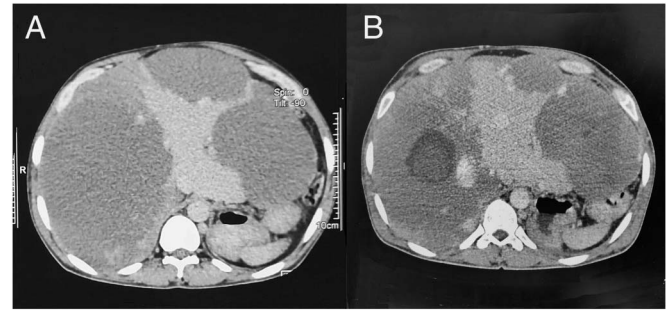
Multidetector computed tomography axial image of the patient's brother showing (A) multiple giant hemangiomas occupying the right and left liver and (B) after 1 session of radiofrequency ablation of right-side hemangioma.
